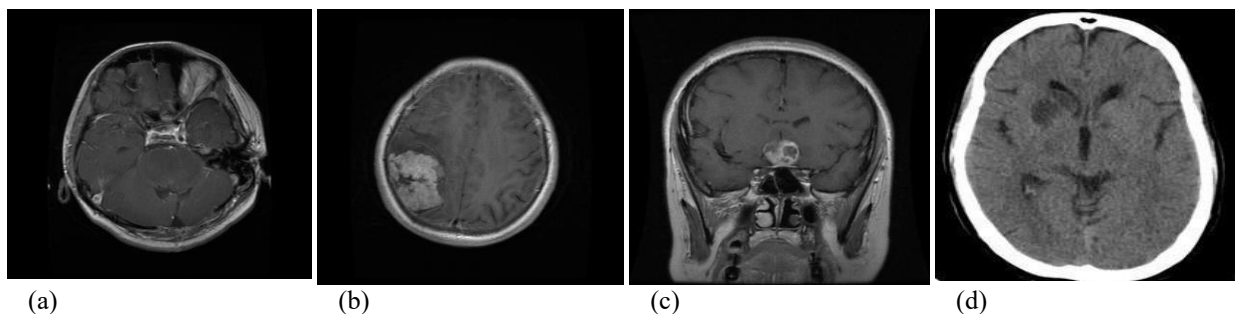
Multi-modal neuroimaging samples across dataset classes: (a)–(c) Contrast-enhanced MRI slices showcasing glioma, meningioma, and pituitary tumors respectively, and (d) non-tumor CT scan.
